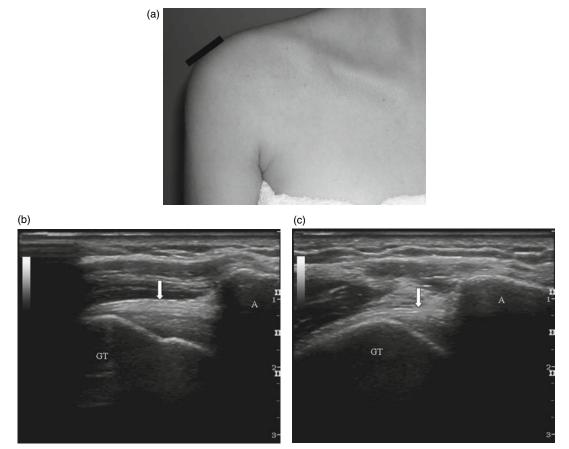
Supraspinatus dynamic impingement test: (a) transducer position and (b) corresponding ultrasound image in the longitudinal plane of the tendon in the neutral position and (c) in abduction. The supraspinatus tendon should move smoothly under the acromion without bunching of its fibers, lateral distention of the overlying SASD bursa, or superior translation of the humeral head. A, acromion; GT, greater tuberosity.
